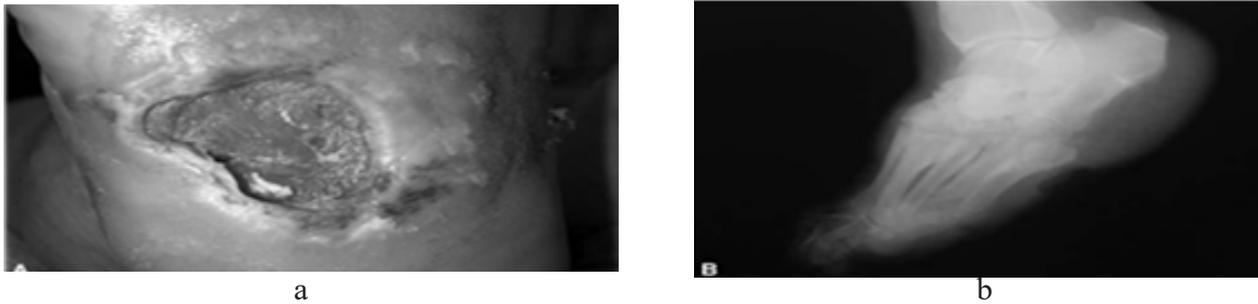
a) ulcer of plantar foot surface in diabetic patient, diameter 5 cm, before the treatment with growth factor, b) X-ray of right foot: Charcot arthropathy at the right tarsus, without findings of active osteomyelitis
